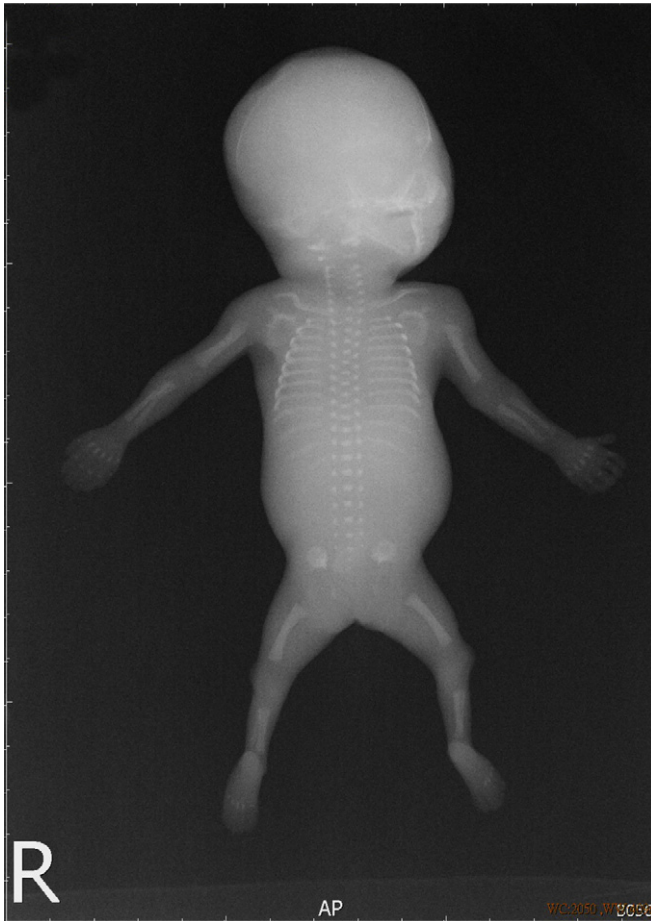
The corresponding roentgenogram.
